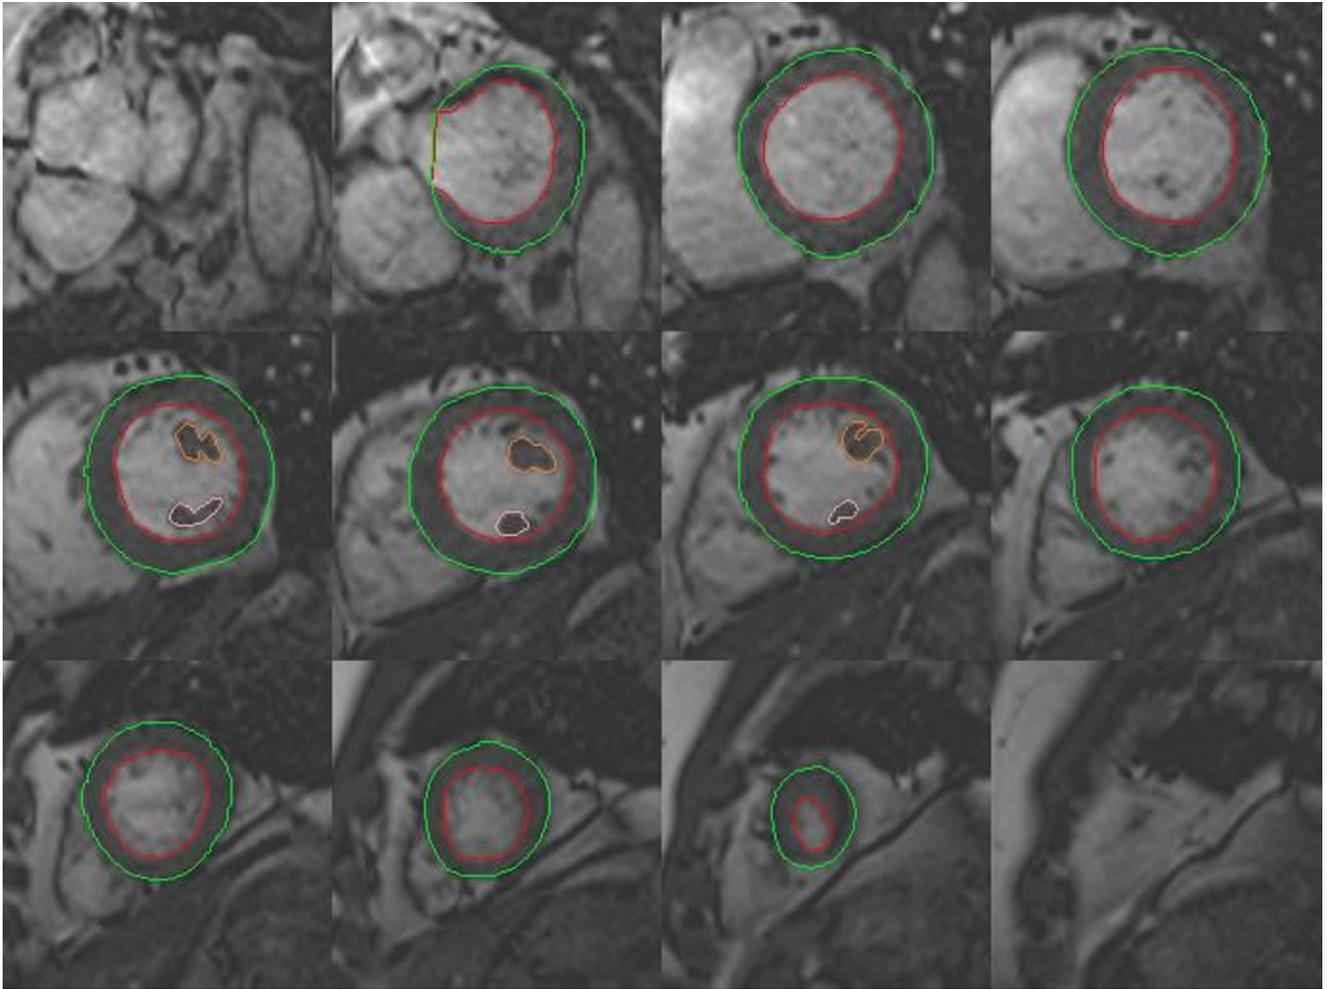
LV short-axis images taken from the base of the heart to the apex using a standard steady-state free-precession multiphase, multislice MRI sequence. Endocardial and epicardial contours are shown outlined in end diastole, enabling accurate calculation of LVM.
